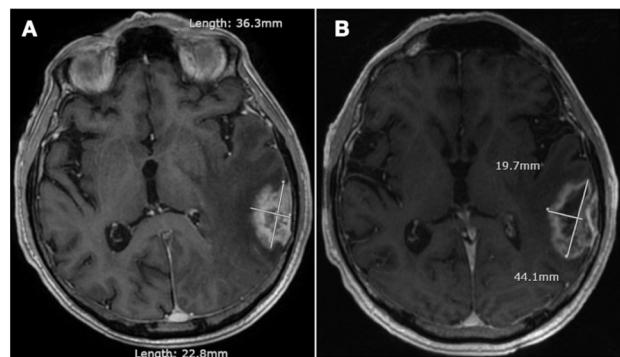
(A) Axial T1-weighted MRI of the head with contrast showing a large mass with a broad dural base overlying the lateral left temporal and occipital lobe. (B) Axial T1-weighted MRI of the head with contrast showing an area of heterogeneous enhancement within the left temporal lobe representing radionecrosis 8 months after completion of stereotactic radiation.
